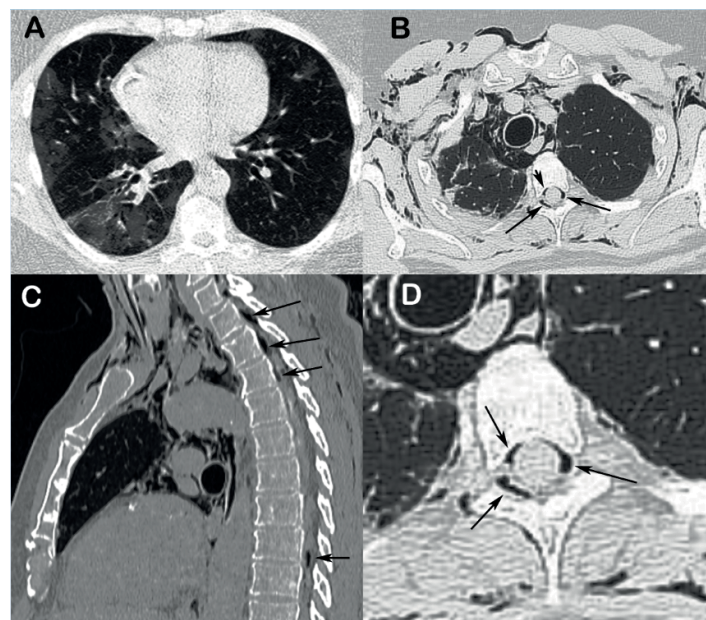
(A), chest CT (axial reconstruction) showing right-sided predominant ground-glass opacities in both lungs. Chest CT with axial (B) and sagittal (C) reconstructions performed two weeks later, demonstrating subcutaneous emphysema, pneumomediastinum, and pneumorrhachis (arrows); (D), spot film demonstrating a large amount of air within the spinal canal (arrows).
